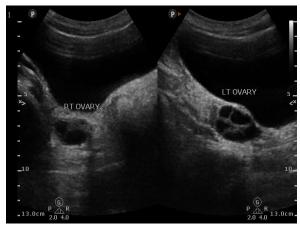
Ultrasound image of bilateral ovaries.
